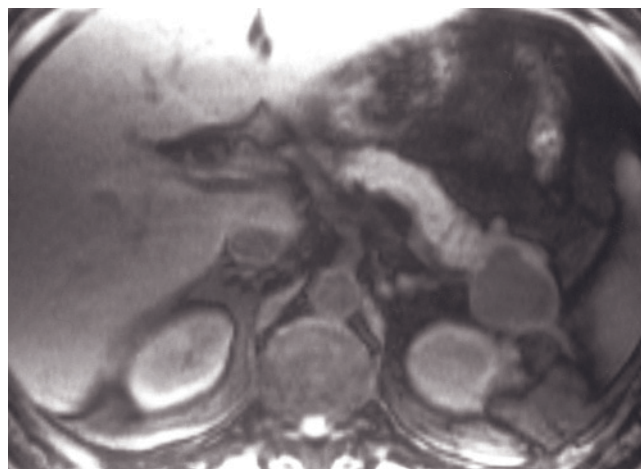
(Continued) is normal in signal on noncontrast T1-weighted fat-suppressed images (*e*) and enhances normally on early (*f*) and late (*g*) images, consistent with no substantial parenchymal disease. There is progressive enhancement of the wall of the pseudocyst (*g*), which is typical for fibrous tissue. The pancreas, spleen, and liver are mildly hypointense on T2-weighted images (*d*) secondary to iron deposition from multiple blood transfusions.
